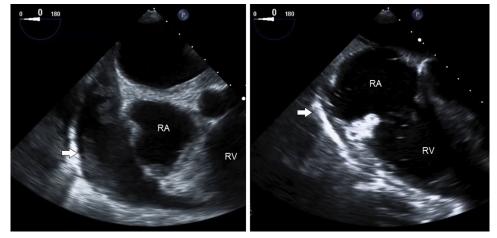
Midesophageal view on transesophageal echocardiography shows a mass on the anterior mitral annulus (*white arrow*) at the time of diagnosis (*left*). The *right* is a similar view after completion of antimicrobial therapy showing marked improvement in the appearance of the mitral annular mass (*white arrow*).
